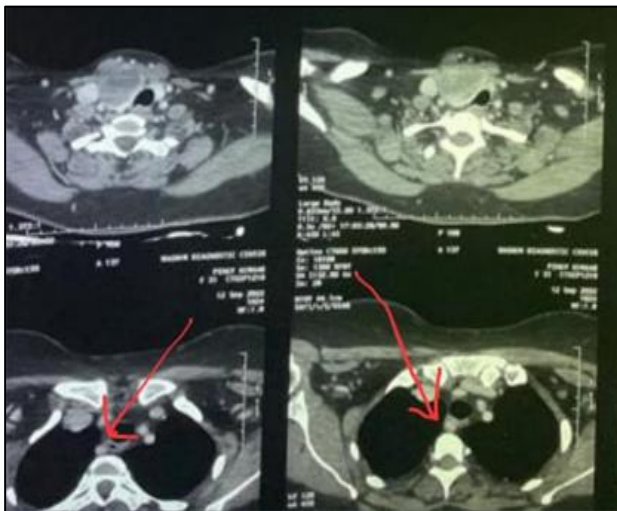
Contrast CT scan neck showing well defined heterogeneously enhancing lesion in both lobes of thyroid predominately left lobe and aberrant origin of right subclavian artery.
